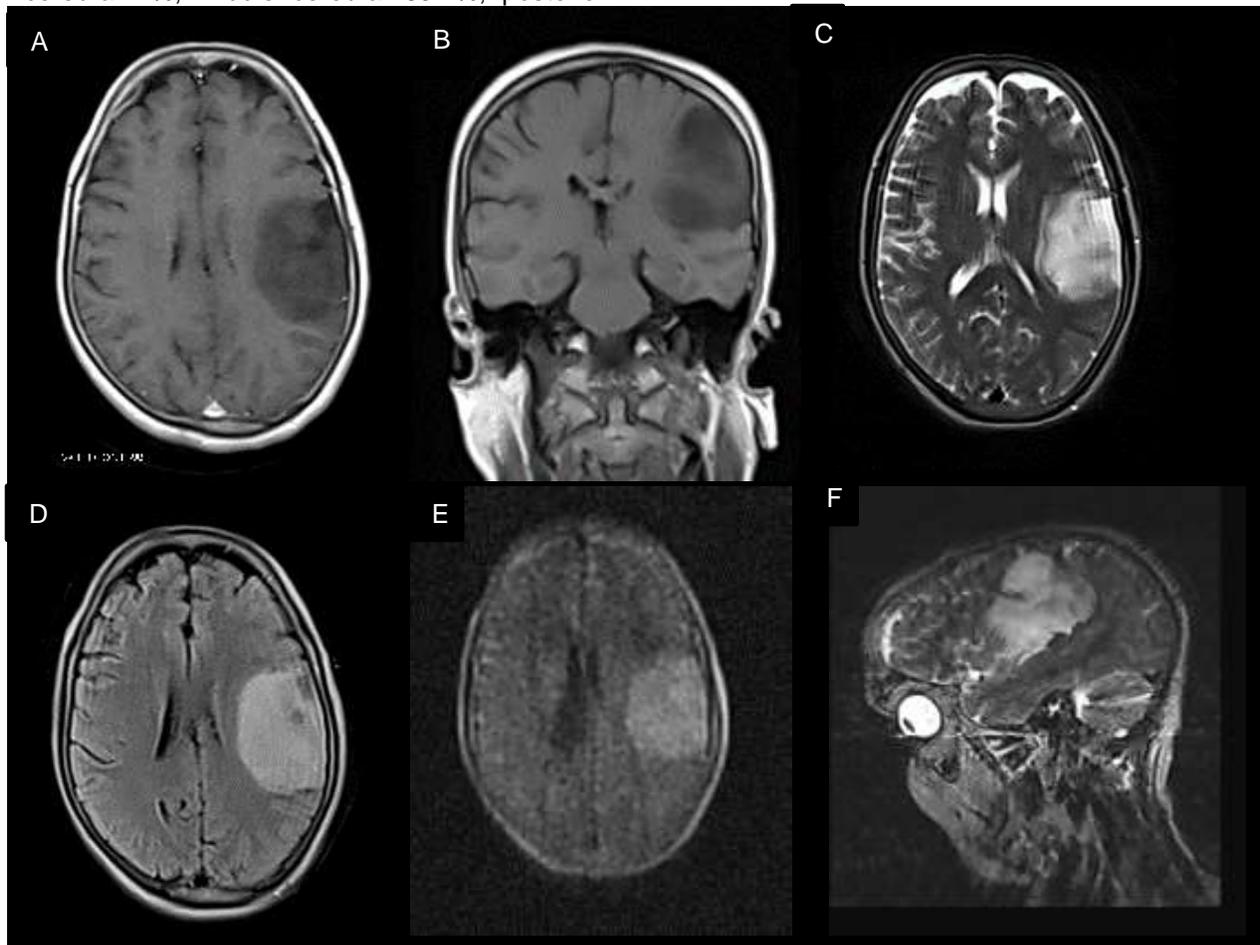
(A) a hypointense lesion occupying a large area of the left hemisphere on the T1 axial sequence (B) this coronal image of MRI shows a hypointense (dark) lesion in the left side of the brain in the temporal lobe on T1 sequence of MRI. (C) this axial image shows a hyperintense lesion on T2 sequence of MRI (on the left side of brain in the temporal lobe) (D) this axial image of MRI shows a hyperintense (bright) lesion in the left side of the brain in the temporal lobe on FLAIR sequence of MRI (E) this axial image shows a hyperintense lesion on DWI sequence of MRI (temporal lobe) (F) this sagittal image shows a hyperintense lesion on DWI sequence of MRI
